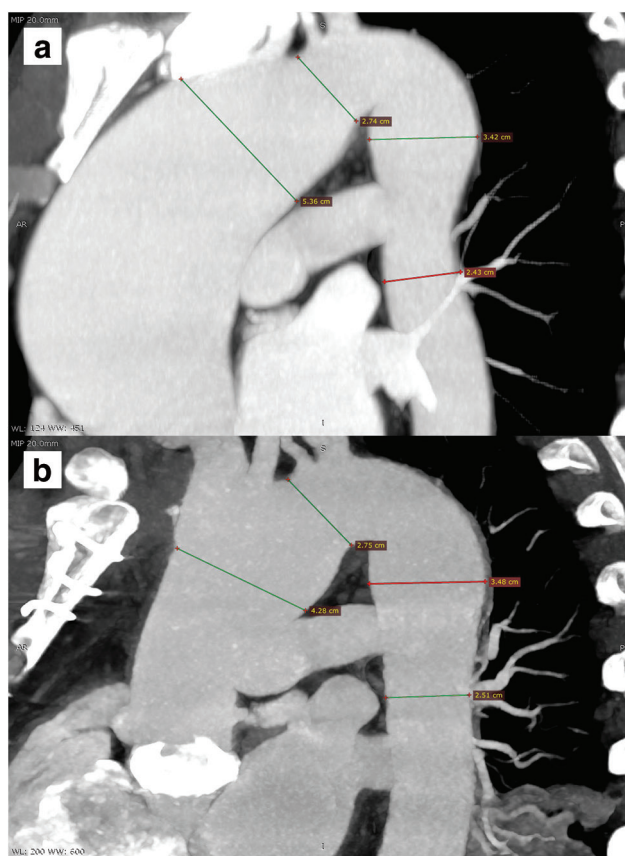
(a) Preoperative CT (sagittal plane) with marks of dimensions of the distal ascending aorta (5.36 cm), the middle of the aortic arch (2.74 cm), the distal aortic arch (3.42 cm), and the thoracic descending aorta (2.43 cm). (b) Postoperative 3-year follow-up CT (sagittal plane) with the same marks: 4.28 cm, 2.75 cm, 3.48 cm, and 2.51 cm, correspondingly. (c) Preoperative and 3-year follow-up aortic segment dimensions in graphics. CT: computed tomography
